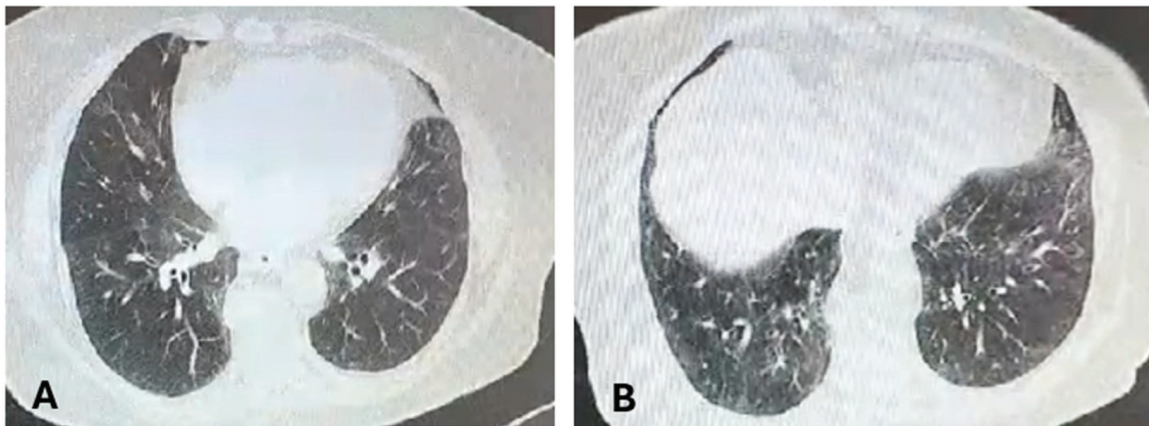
Chest CT September 2021. (A) Unsystematized bilateral ground-glass pulmonary infiltrates; (B) bilateral basal ground-glass pulmonary infiltrates.
